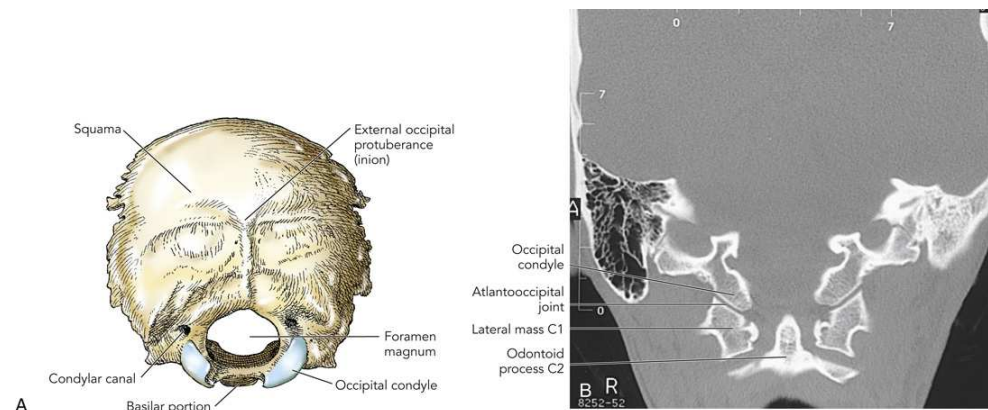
(A) External surface of occipital bone. (B) Coronal CT showing atlantooccipital joint. B, Courtesy Siemens Medical Systems, Iselin, NJ.
